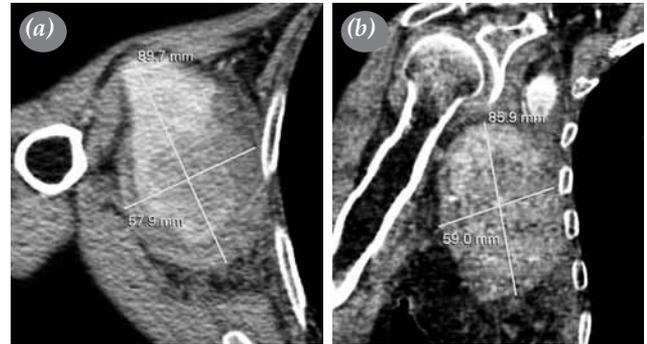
Computed tomography shows the size of the hematoma. (a) The transverse plane of the hematoma measured 90x58 mm while (b) the coronal plane of the hematoma was 59x86 mm.
